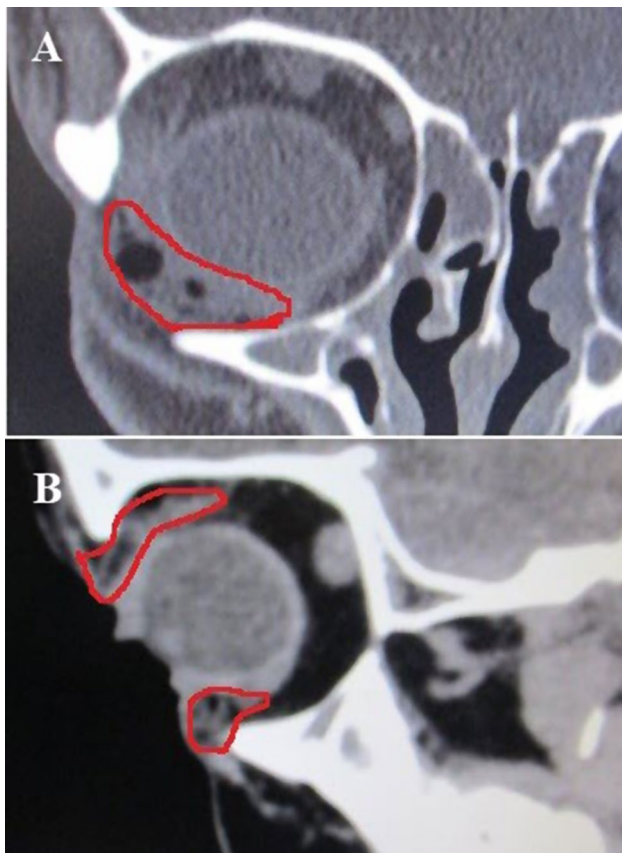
(A) Coronal Orbital CT scan show are of round hypodense are within eyelid which correspond to paraffinoma. (B) Sagittal images show extension into anterior orbital cavity
